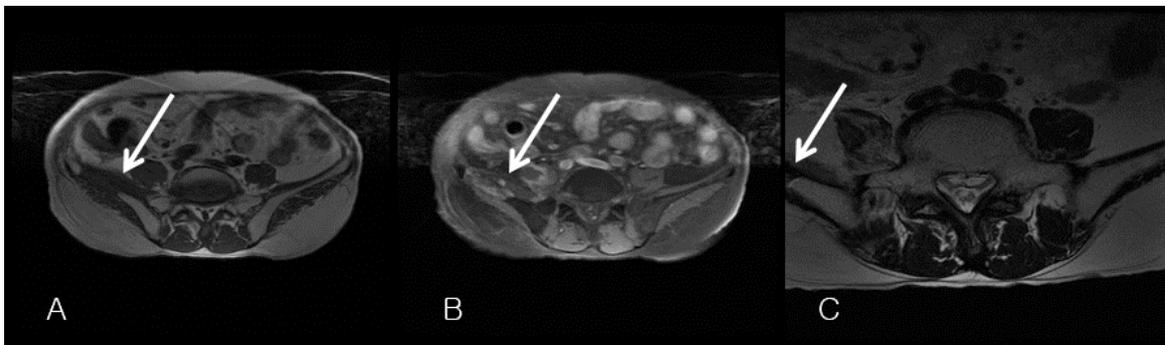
Representing Rt. Psoas, iliacus muscle and iliac bone metastasis 1A. MRI T1 FSE image, 1B. MRI T1 Fat sat FSE image, 1C MRI T2 image
